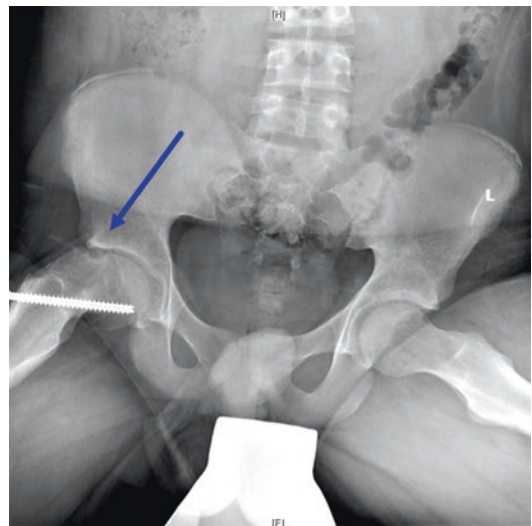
Pelvis X-ray shows impingement of femoral neck over the acetabular socket. This is a 16-year-old boy who had SCFE pinned in situ 2 years ago. He is symptomatic. Maximum flexion is 70°, no internal rotation and 30° abduction
